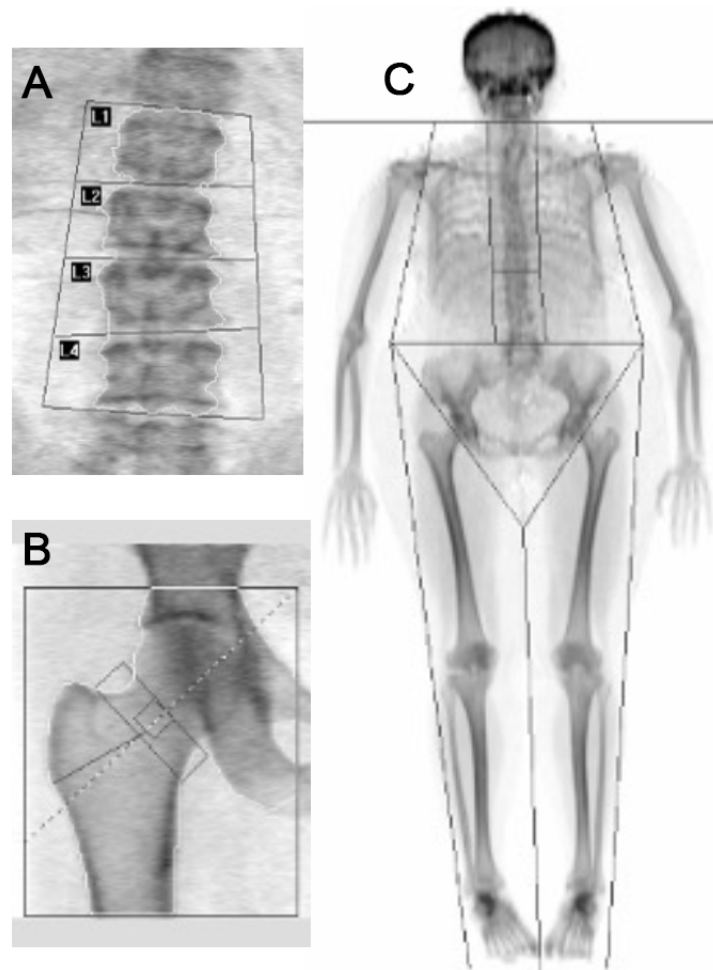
Dual-energy X-ray absorptiometry (DXA) for measuring BMD of the spine at the level of L1–L4 (A), femoral neck (B), and whole body (C).
